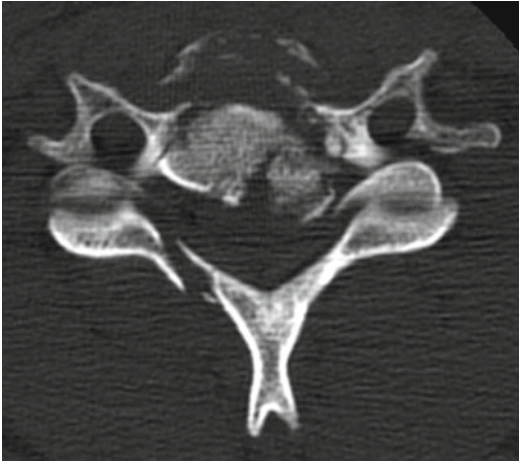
CT scan shows injury to anterior and posterior elements
